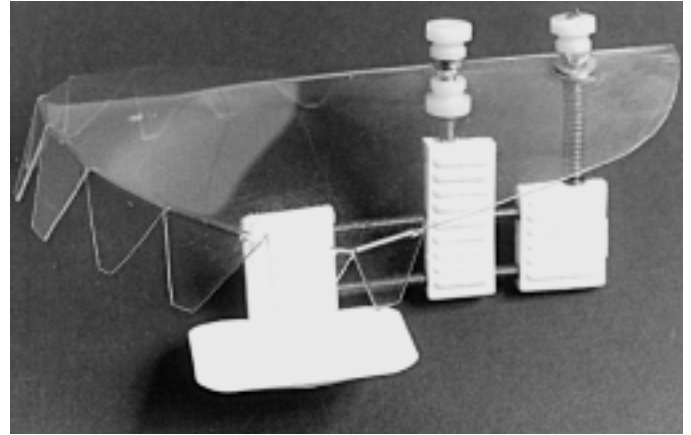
Close-up picture of modified Rinn XCP posterior periapical film holder.
